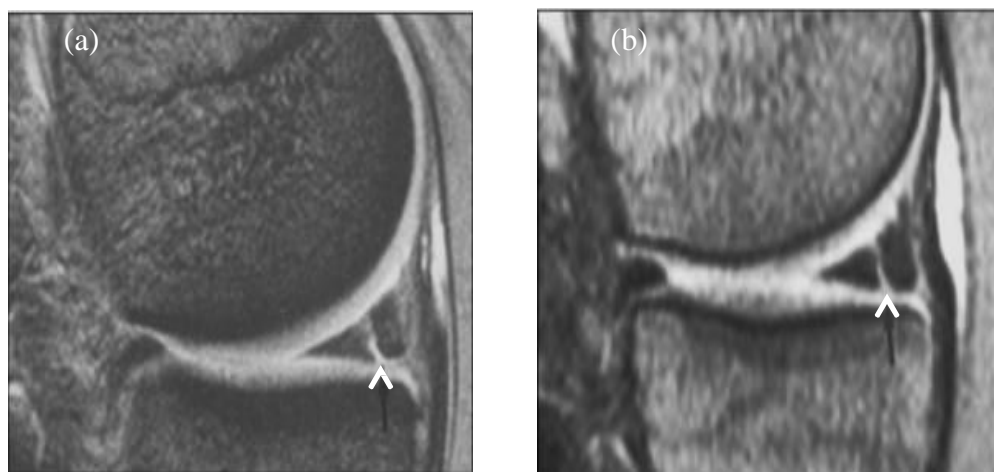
1 MRI images (a) 1.5 T MRI and (b) 0.2 T MRI show equally diagnostic performance on the meniscal injuries (arrow). Adapted from Cotten et al., 2010
